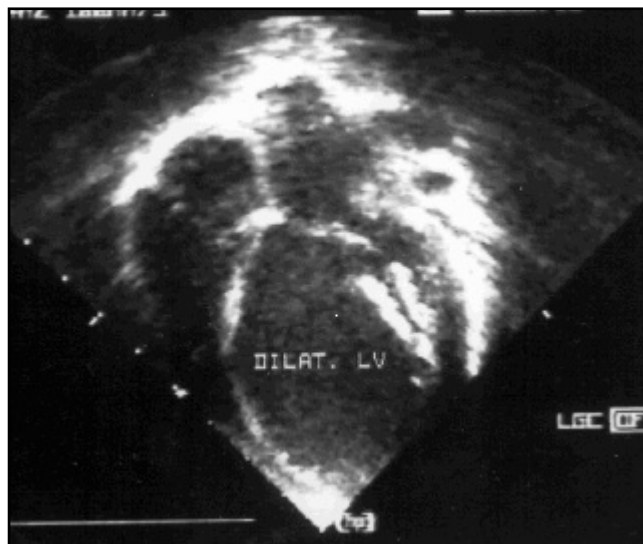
Echocardiography revealing left ventricular dilatation.
